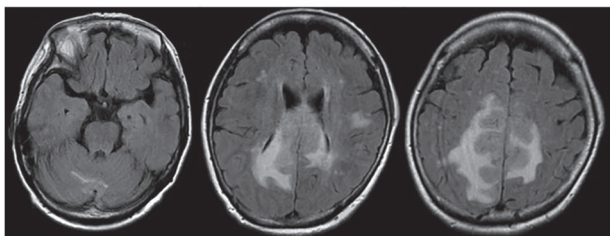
Brain MRI findings. Brain MRI findings of CNS relapse are shown.
